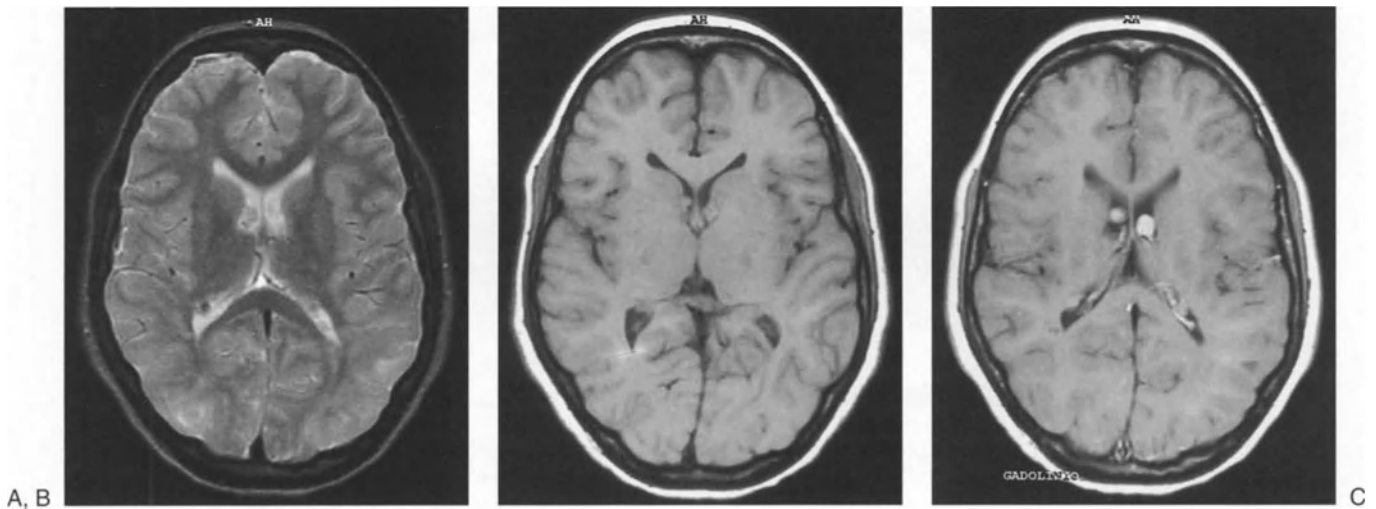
This is another child with Bourneville’s disease, from whose MRI scan these axial sections are herein reproduced. A T2 weighted image (A) reveals multiple subependymal nodules with low signal. In (B), T1, the nodules are shown
